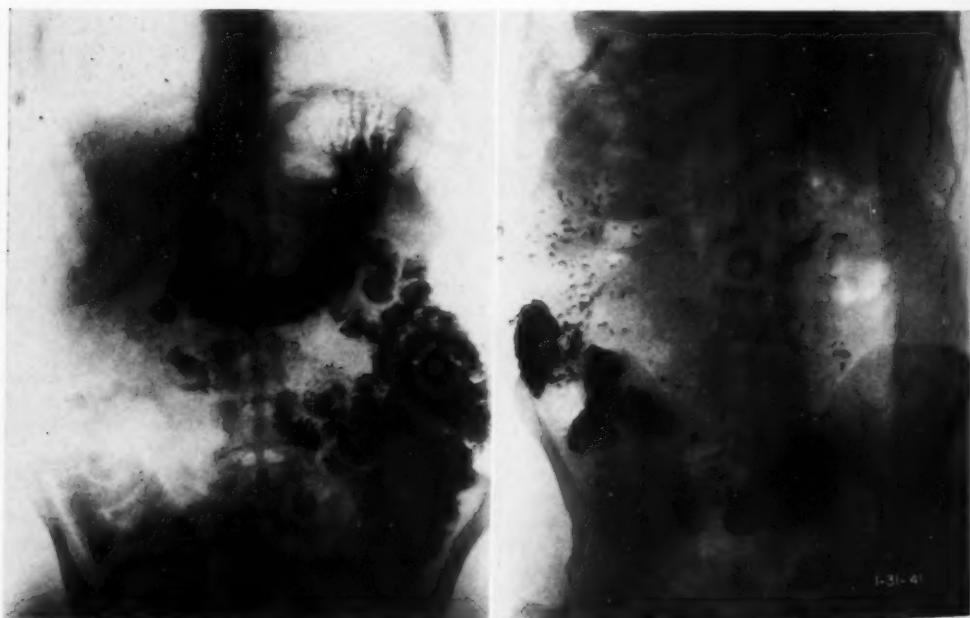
Case 4: Non-tropical sprue. No response to liver therapy. Marked improvement on a celiac diet. (Roentgenogram on the left was made in 1942.)
